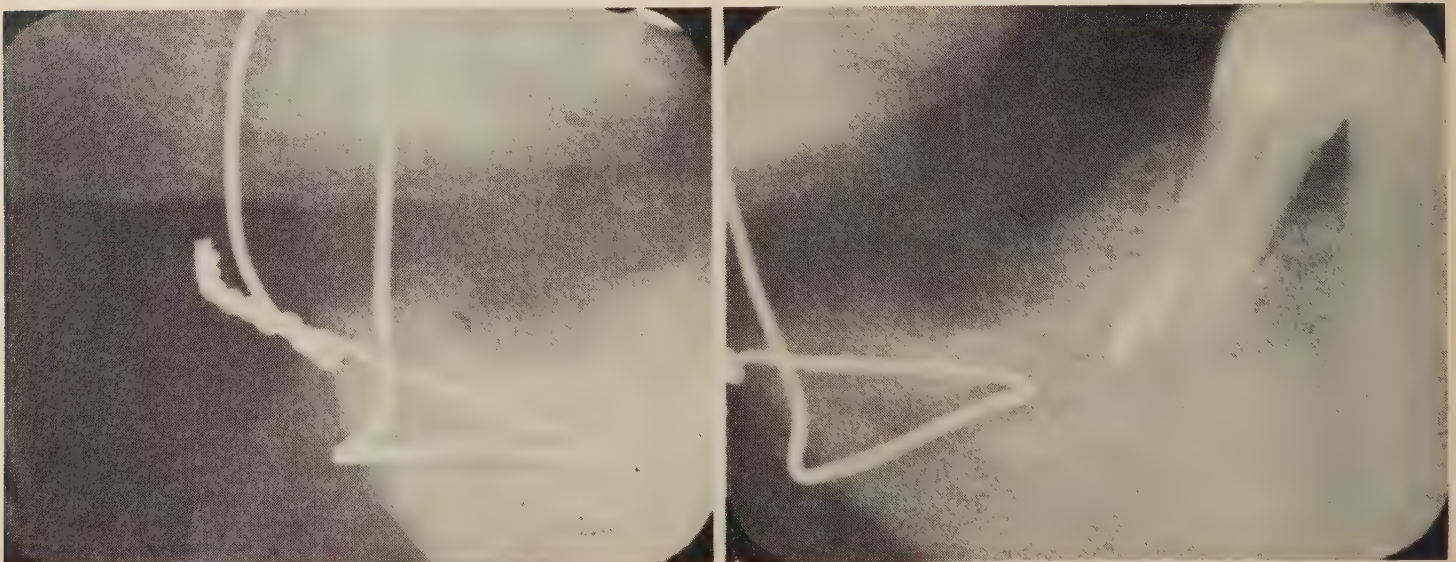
Radiographs taken on January 31, 1964, show progressive destruction of mandible, including lower border.
